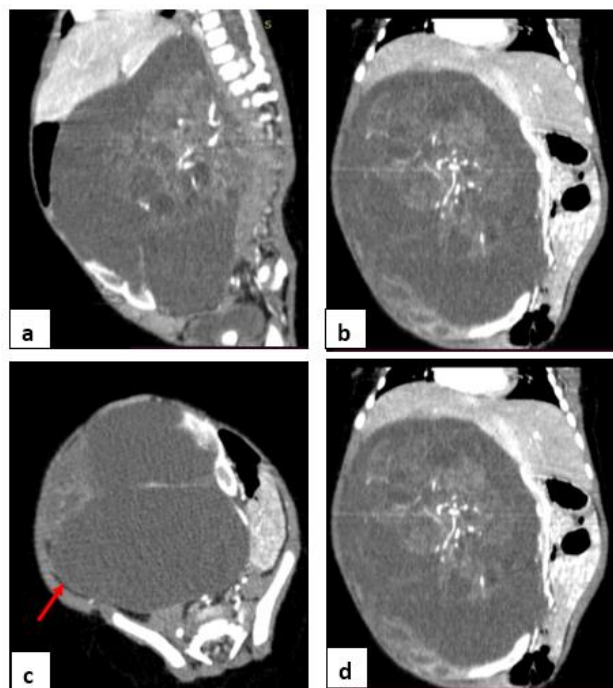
CT axial slices without and after PDC injection (arterial and portal time): Large mass in the right retroperitoneal space. The mass is heterogeneous, solid-cystic, with linear and nodular calcifications, associated with fatty flares at its center, enhanced after injection of PDC and responsible for significant dilatation of the homolateral pyelocalic cavities (arrow), pushing back the large vessels (VCI, aorta).
